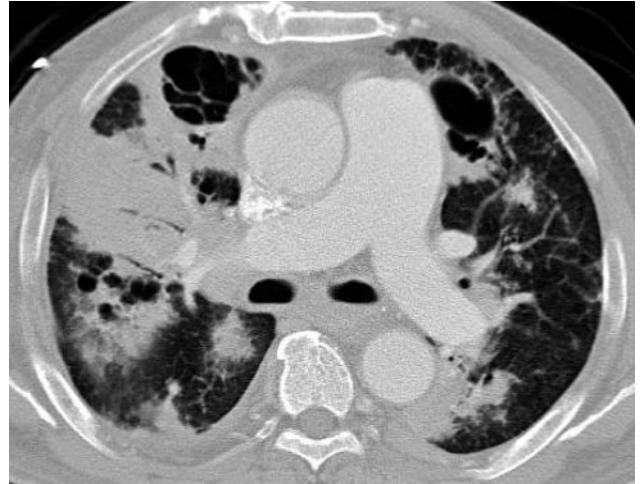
Chest computed tomogram shows multiple masses, some with air bronchograms and small cavities.
